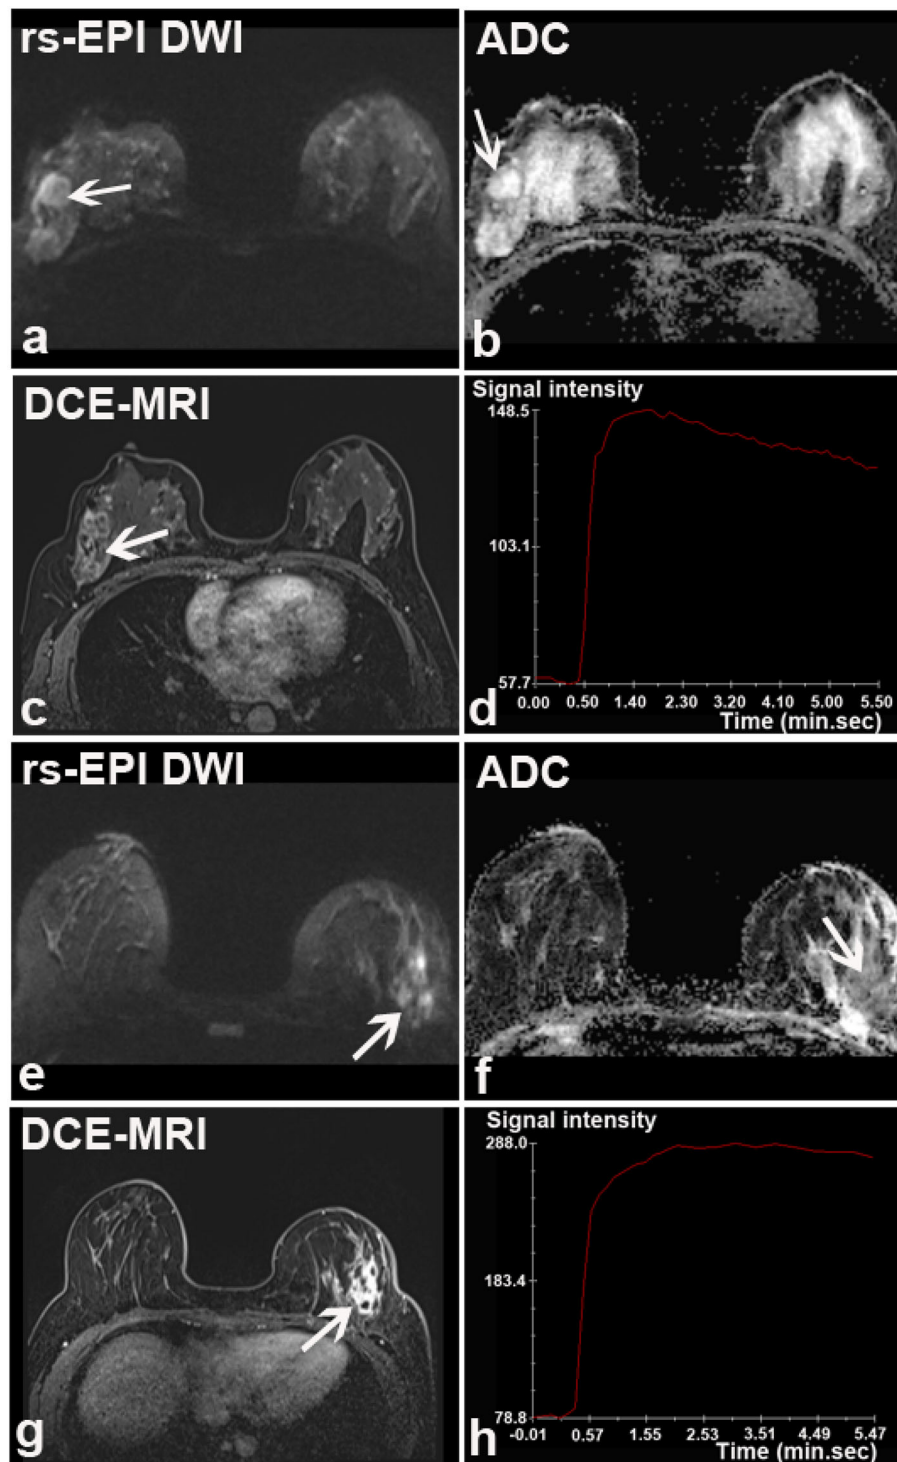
Two breast lesions falsely classified by rs-EPI DWI in two patients. (a–d) rs-EPI DWI (b -value, $1,000 \text{ s/mm}^2$), ADC map, DCE-MRI, and time-signal intensity curve (TIC) from a 46-year-old woman with the right breast mucinous carcinoma. (a) rs-EPI DWI shows a lesion with an irregular shape and heterogeneous internal structure, but high signal on ADC map (arrow) (b). The lesion was considered as fibrocystic hyperplasia and rated as BI-RADS 3. (c) DCE-MRI shows that this lesion has an irregular shape and heterogeneous signal enhancement (arrow) with initial fast enhancement followed by washout (d). Thus, lesion was categorized as BI-RADS 4. (e–h) rs-EPI DWI (b -value, $1,000 \text{ s/mm}^2$), ADC map, DCE-MRI, and TIC from a 33-year-old woman with the left breast granulomatous mastitis accompanying a small abscess. (e) rs-EPI DWI shows irregular high signals with markedly low signal on ADC map (arrow) (f). Lesion was categorized as malignancy based upon rs-EPI DWI. (g) DCE-MRI shows non-mass-like enhancement with segmental distribution (arrow) and initial fast enhancement followed by plateau (h), thus categorized as BI-RADS 4.
